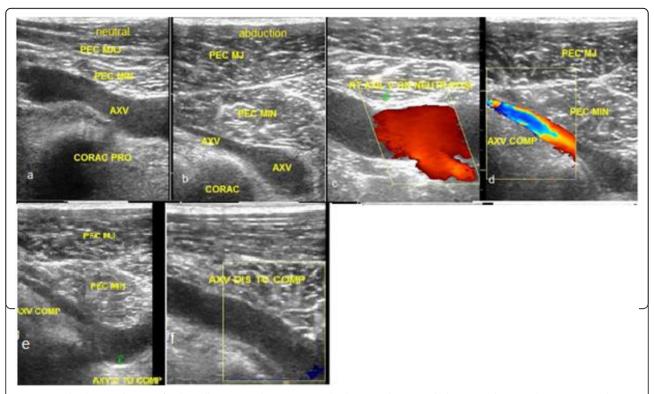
B-mode ultrasound images for the axillary vein in the retro-pectoral\sub-coracoid space with the arm in the neutral position (a) and in arm abduction (b) showing marked compression of the vein by the overlying pectoralis minor muscle. Color Doppler images with the arm in the neutral (c) and in the abduction (d) positions showing significant stenosis with color aliasing in the compressed vein segment by the overlying pectoralis minor muscle. B-mode and color Doppler images of the axillary vein distal to the compression level showing the vein distension (e) with almost total cessation of the venous flow with the hyper-abduction (f)
